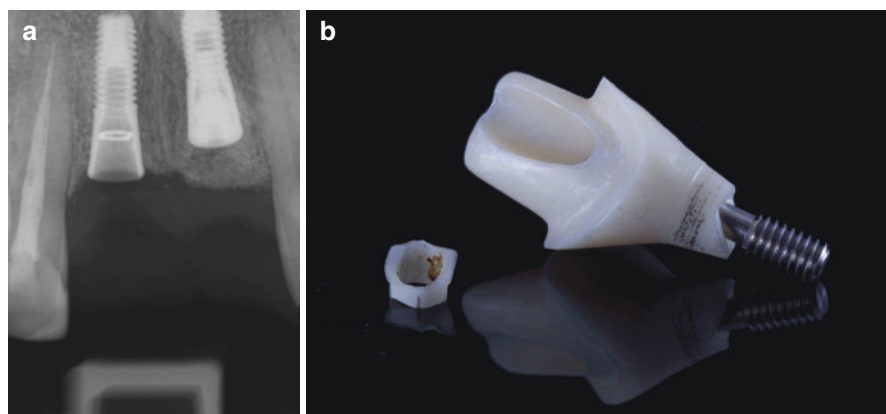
(a, b) A full zirconia abutment has fractured inside the implant connection. The use of abutments without a Ti Base is risky due to this potential complication. The apical portion of the fractured zirconia abutment is visible on the radiograph as a radiopaque ring. Such fractures can be difficult to treat, as the remaining zirconia portion may be wedged in place requiring drilling to remove (courtesy of Dr. David Wagner)
